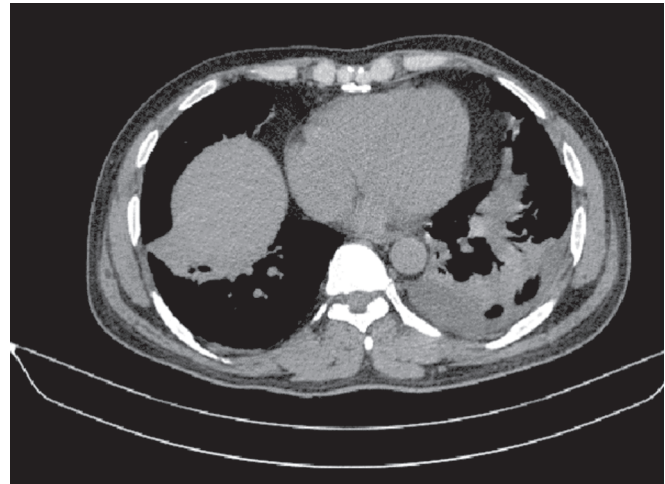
High resolution computed tomography (HRCT) chest plain
